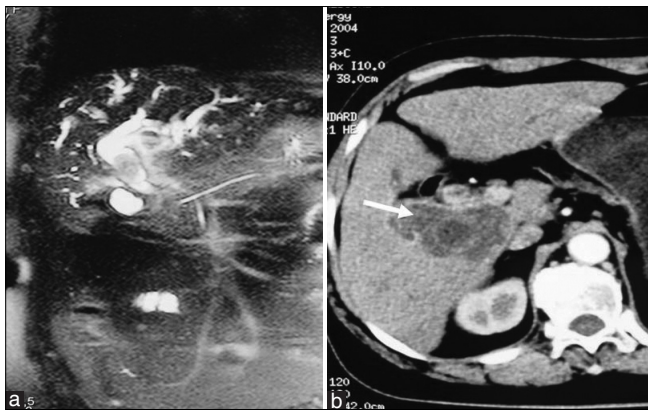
(a) In MRCP photograph, the arrow points at the filling defect in the CBD, (b) In CT photograph, the arrow points at the gallbladder cancer invasion in the right lobe and caudate lobe of the liver
